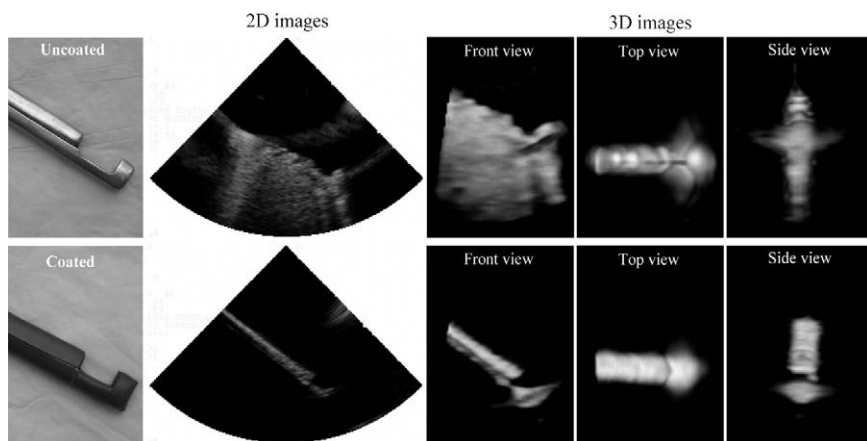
Effect of polyurethane foam coating on suturing device imaging. (Top row) Uncoated. (Bottom row) Coated with polyurethane foam. (Reprinted with permission from Huang et al,³¹ ©2007 American Institute of Ultrasound in Medicine.)
